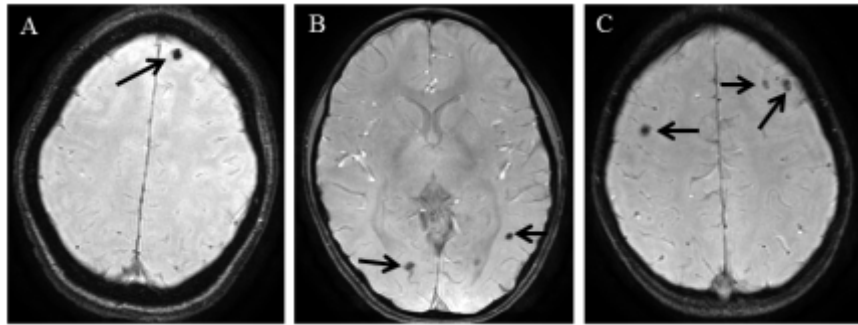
Magnetic resonance image of symptomatic patients with neurocysticercosis showing cysticerci in the brain parenchyma. T2-weighted axial images at different sections show (A) single cyst, (B) two and (C) multiple cysts.
